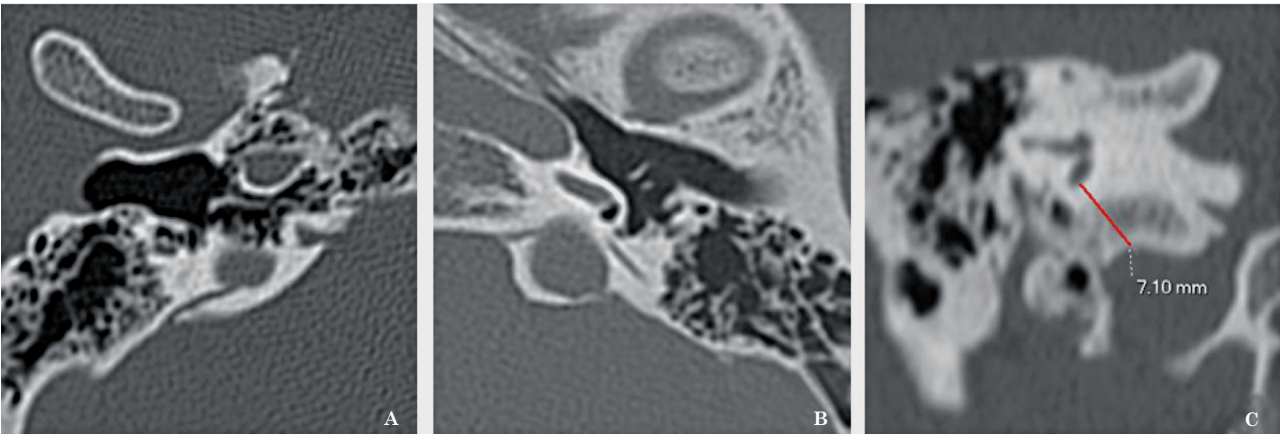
Axial and coronal CT images. A) Dehiscence of the jugular bulb with the vestibular aqueduct. B) 45-year-old female with recurrent dizziness not responding to drug therapy. CT images show enlarged JB dehiscence with both cochlear and vestibular aqueducts. C) Distance between jugular bulb and posterior semicircular canal bony wall.
